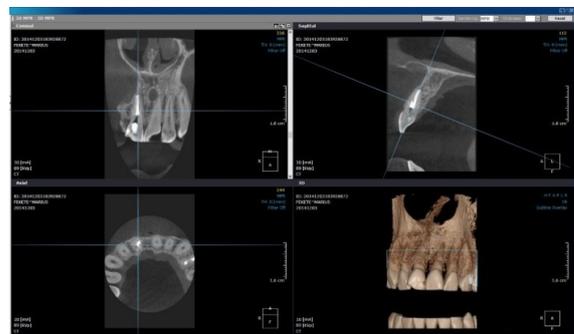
The case was reevaluated, the true canal was identified and the control CBCT scan confirmed the proper root filling.
